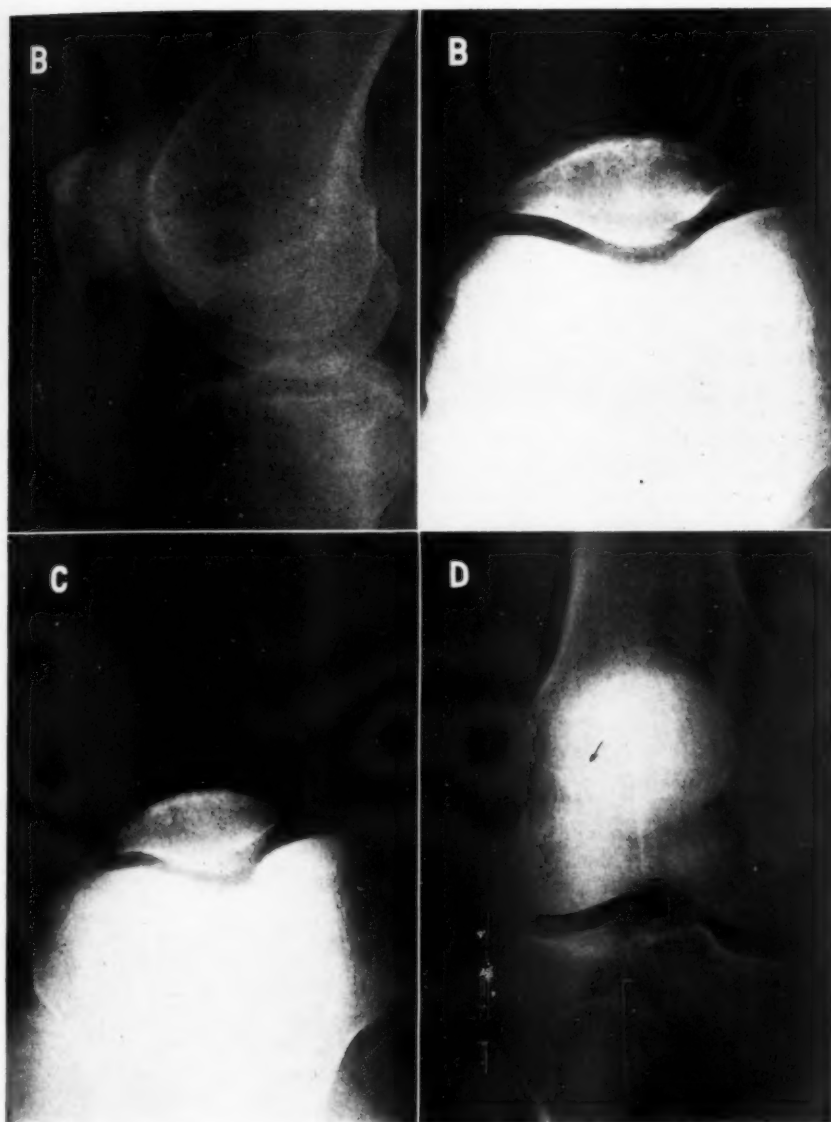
B-D. B. Lateral and tangential views of case shown in Fig. 9A, taken about five weeks later, still revealing no evidence of a fracture. C. One of the tangential views on this re-examination shows the fracture, apparently due rather to an incidental change in position, giving a more nearly parallel projection, than to reparative changes of a true retarded fracture, since other tangential views failed to demonstrate the gap. Note the positional difference between the tangential views. D. An overexposure in the re-examination also shows the fracture line, which is evidently closely parallel with the incident x-ray beam. C and D would have been easily classified as "occult fractures."
